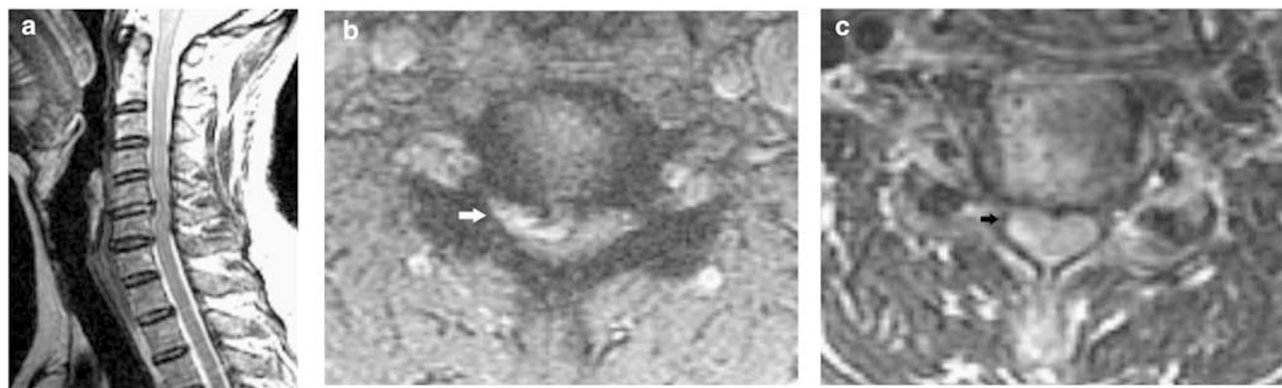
Preoperative T2-weighted sagittal (a) and axial (b) MRI in Case 1 revealing a large C5–C6 disc herniation, compressing the right side of the spinal cord (arrow). T2-weighted axial MRI (c), obtained 1 month after surgery, showing excellent decompression of the spinal cord (arrow)
